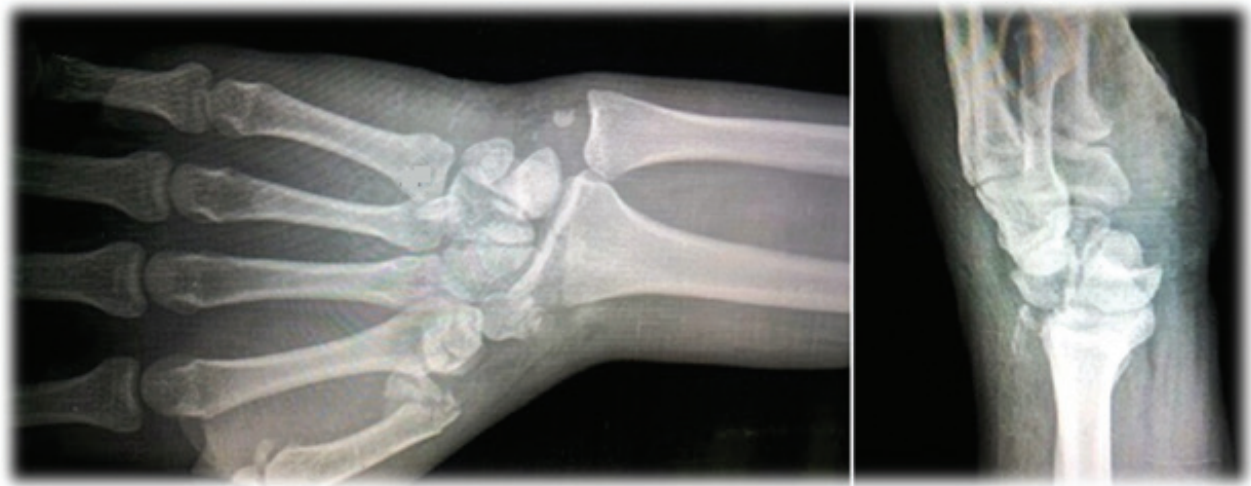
Anteroposterior radiography of the left wrist demonstrating fracture of radial styloid, base of first metacarpal and scaphoid with discontinuity of Gilula lines (A). Lateral radiography of the left wrist demonstrating perilunate dislocation (B).
